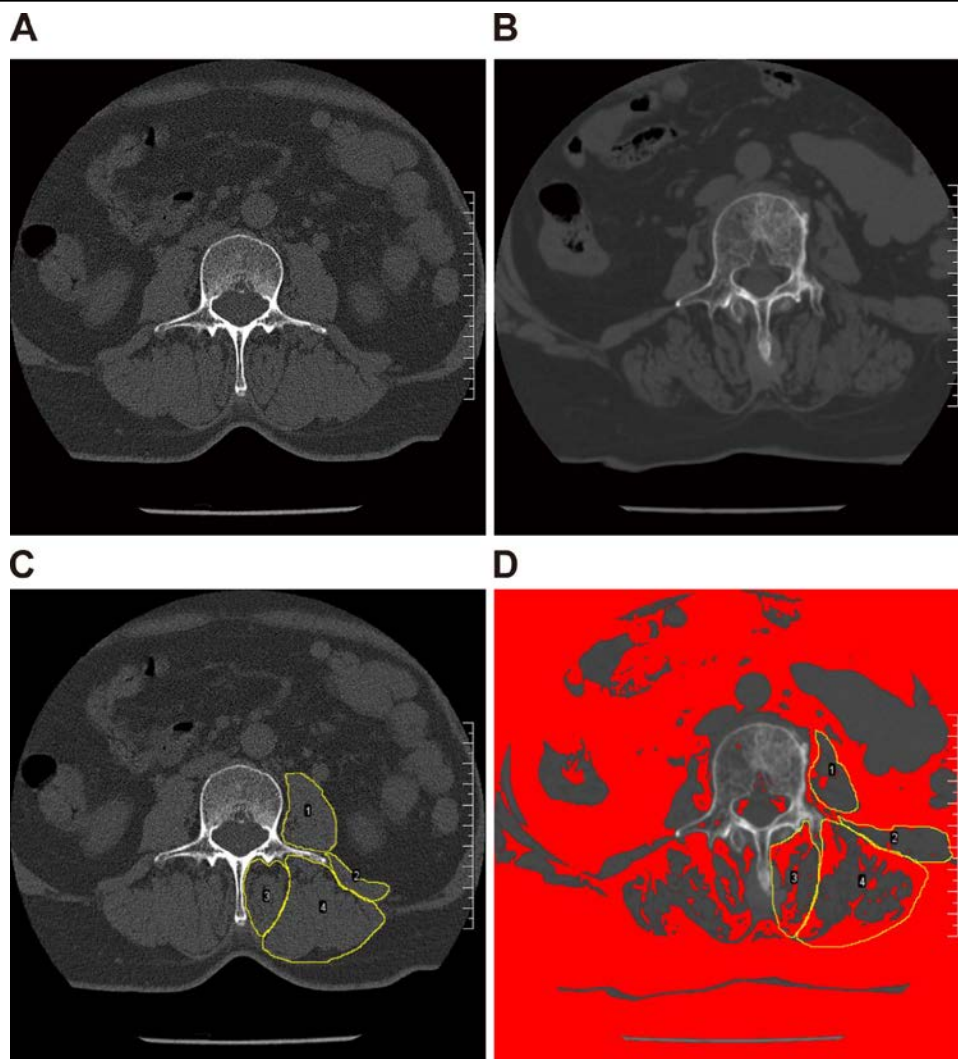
Cross-sectional areas (CSAs) and fatty infiltration (FI) of paraspinal muscle. (A, B) Computed tomography (CT) images at the median level of L3. (A) Paraspinal muscle with little FI. (B) Paraspinal muscle with much FI. (C) CSAs of paraspinal muscle: 1—psoas major (PS); 2—quadratus lumborum (QL); 3—multifidus (MF); 4—erector spinae (ES). (D) FI of paraspinal muscle.
